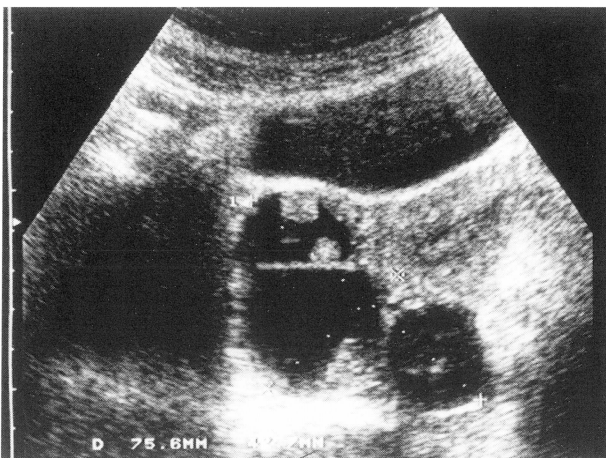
Ultrasound image of the right ovarian pleuricystic structures with endophytic proliferation.
